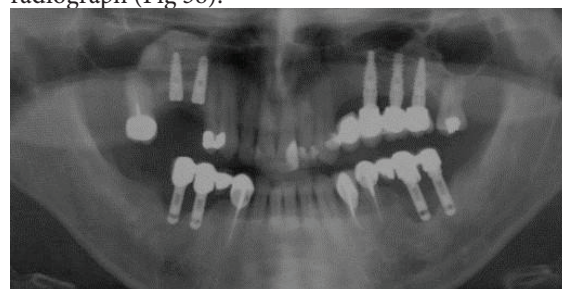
Panoramic radiograph taken 6 months after implants placement and radectomy of the mesial root of the right maxillary second molar showing well-osteointegrated implants into the grafted osteotomy and the grafted sinus at site 15, 16.
